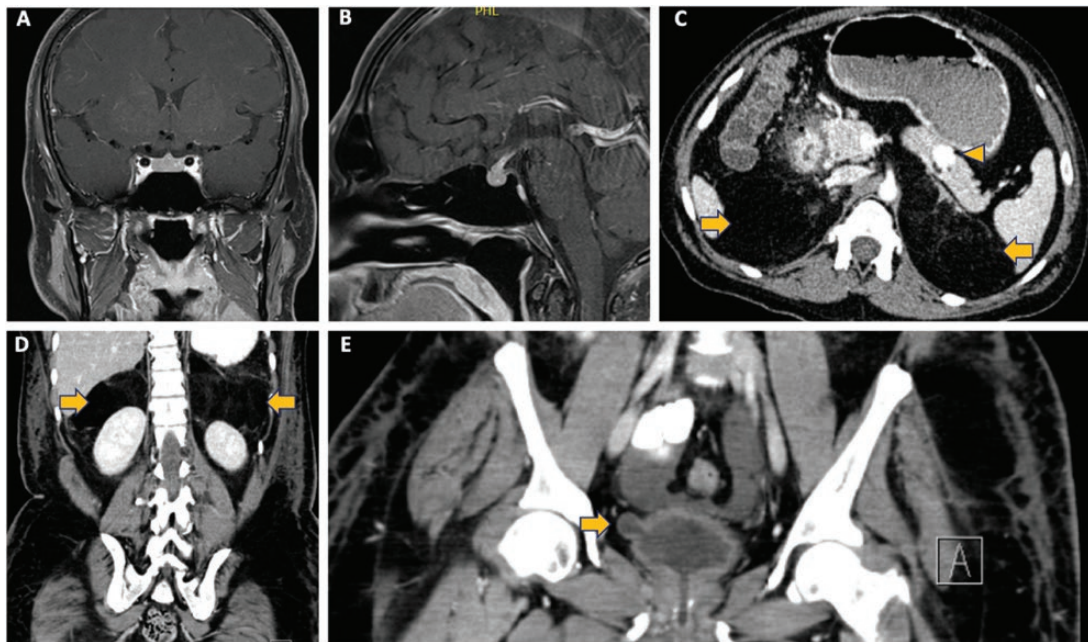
T1 post-contrast pituitary magnetic resonance imaging scan. (A) Coronal view and (B) sagittal view showing a normal-appearing pituitary gland with a prominent infundibulum, but no mass. Computed tomography of the abdomen with (C) transverse and (D, E) coronal view showing bilateral enlargement of the adrenal glands because of adrenal myelolipomas (C-D, arrows, 5.7×10.6 cm on the left and an 8.5×3.7 cm on the right). (C, arrowhead) A 1.6-cm enhancing pancreatic mass and (E, arrow) bladder diverticulum.
